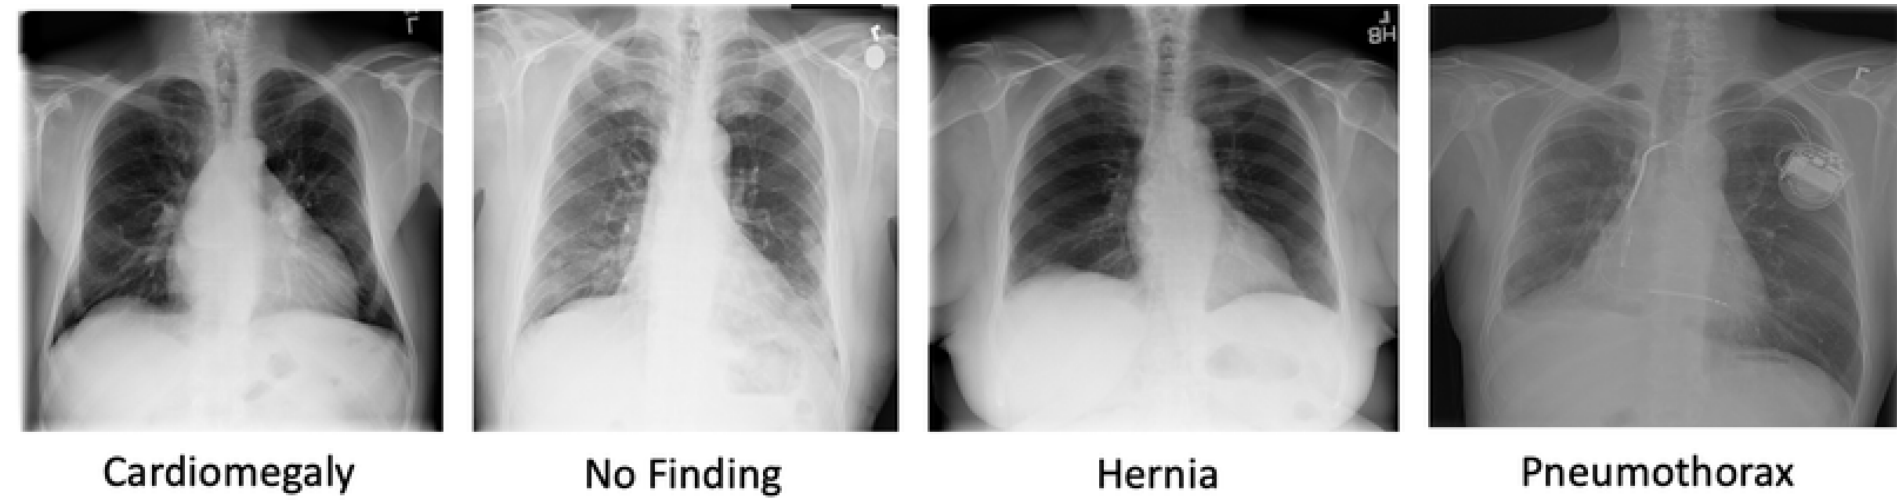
Sample chest X-ray from the NIH ChestX-ray14 dataset.
